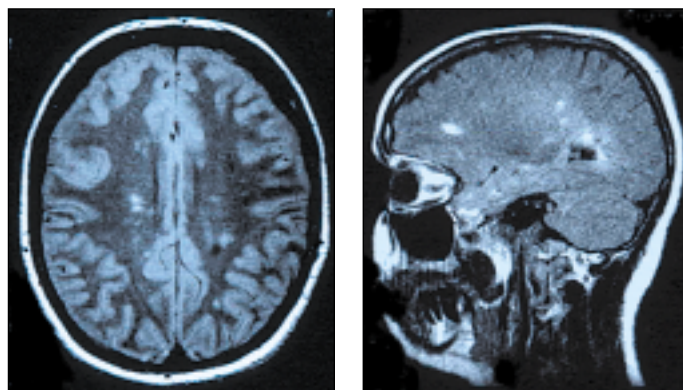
Figure a (Left) Axial and Figure b (Right) sagittal brain MRI showing periventricular cerebral white matter lesions typical of demyelinating disease.
